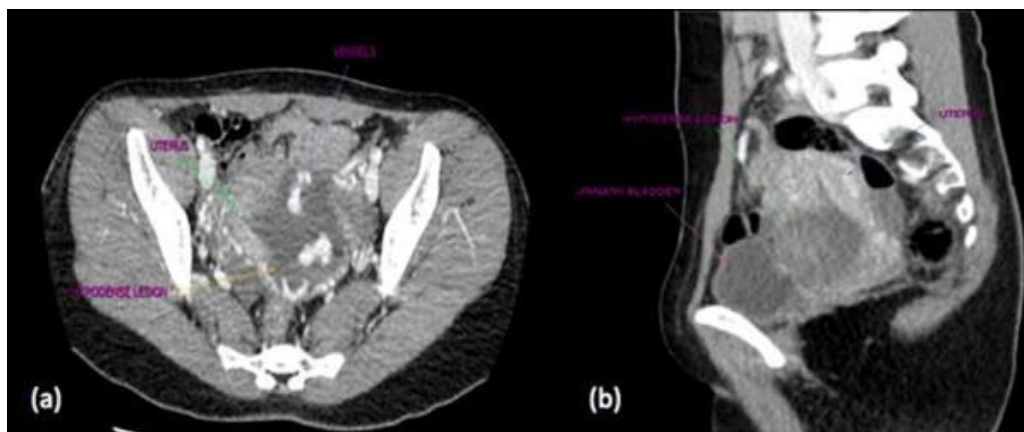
Contrast-enhanced CT of the pelvis at (a) axial view showing a hypodense lesion with tortuous dilated vessels seen traversing within. Dilated vessels are also seen at the parametrium around the uterus. The hypodense lesion pushed the uterus towards the right side. At sagittal view (b), the hypodense lesion was seen with its epicentre within the anterior uterine wall protruding into the uterine cavity
